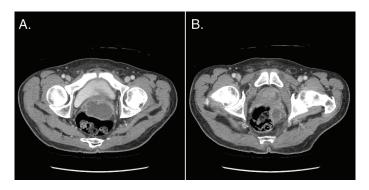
CT reveals genitourinary tuberculosis involving prostate (A) and left seminal vesicle (B). Normal tissues have been replaced with non-enhancing fluid density collections consistent with necrosis.
